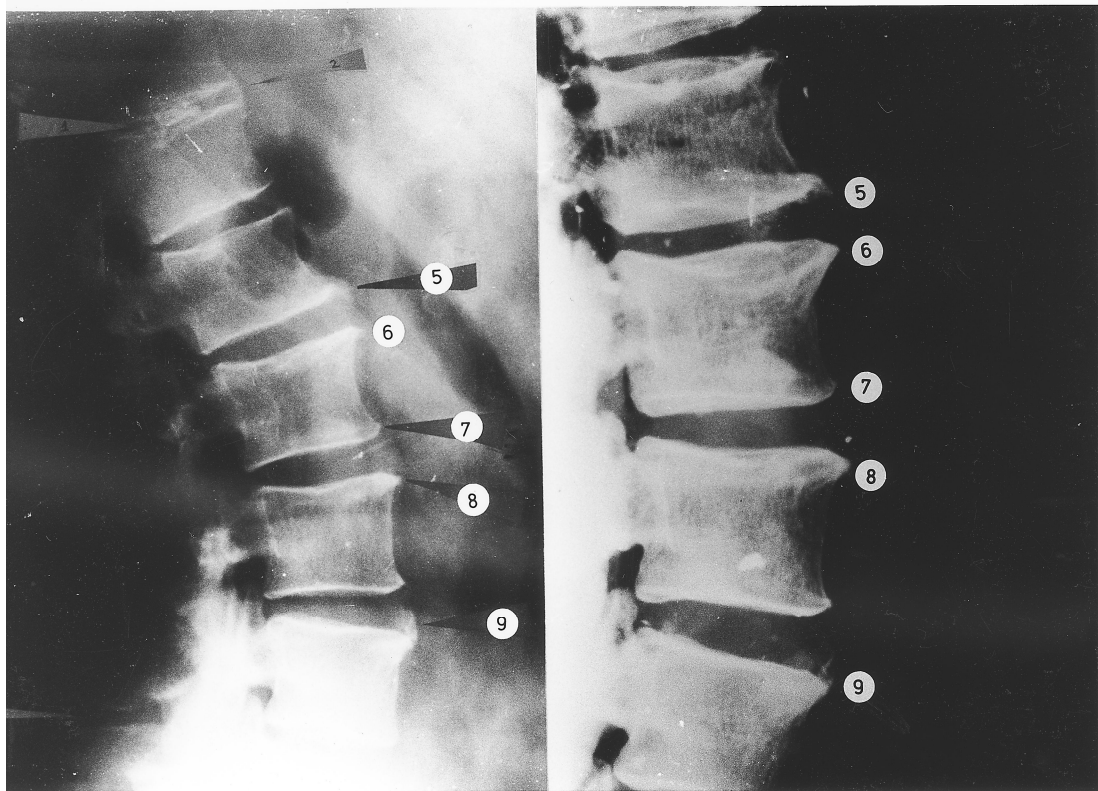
Antemortem (right) and postmortem (left) lateral radiographs of the lumbar spine (numbering corresponds to that in the text).
